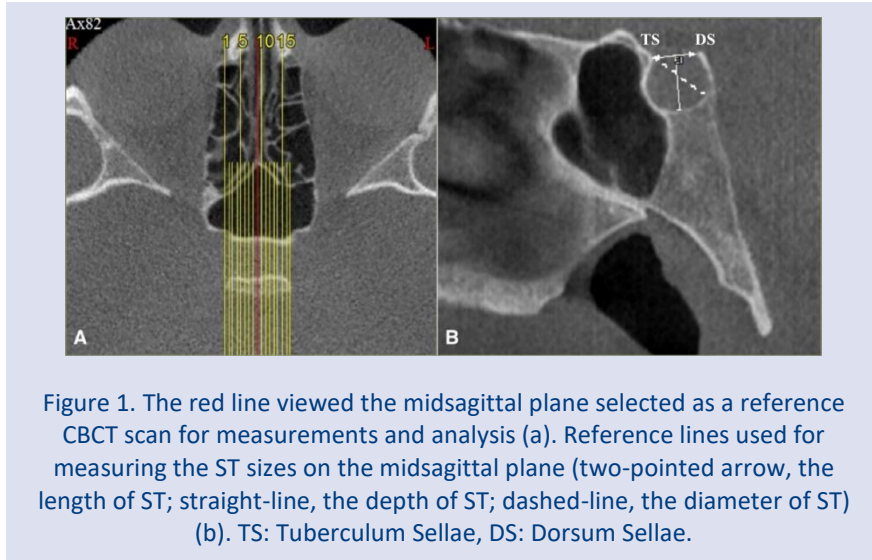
The red line viewed the midsagittal plane selected as a reference CBCT scan for measurements and analysis (a). Reference lines used for measuring the ST sizes on the midsagittal plane (two-pointed arrow, the length of ST; straight-line, the depth of ST; dashed-line, the diameter of ST) (b). TS: Tuberculum Sellae, DS: Dorsum Sellae.
